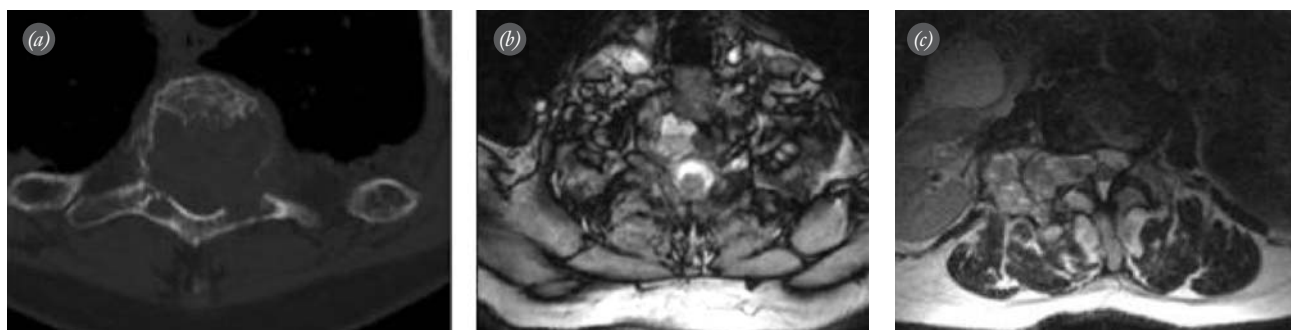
Views from Case 1. (a) Axial CT scan demonstrating a lytic lesion extending to the foramen and destructing the anterior cortex of the lamina. (b) Axial T2-weighted MRI of the same lesion with typical fluid-fluid level in the cystic lesion.
